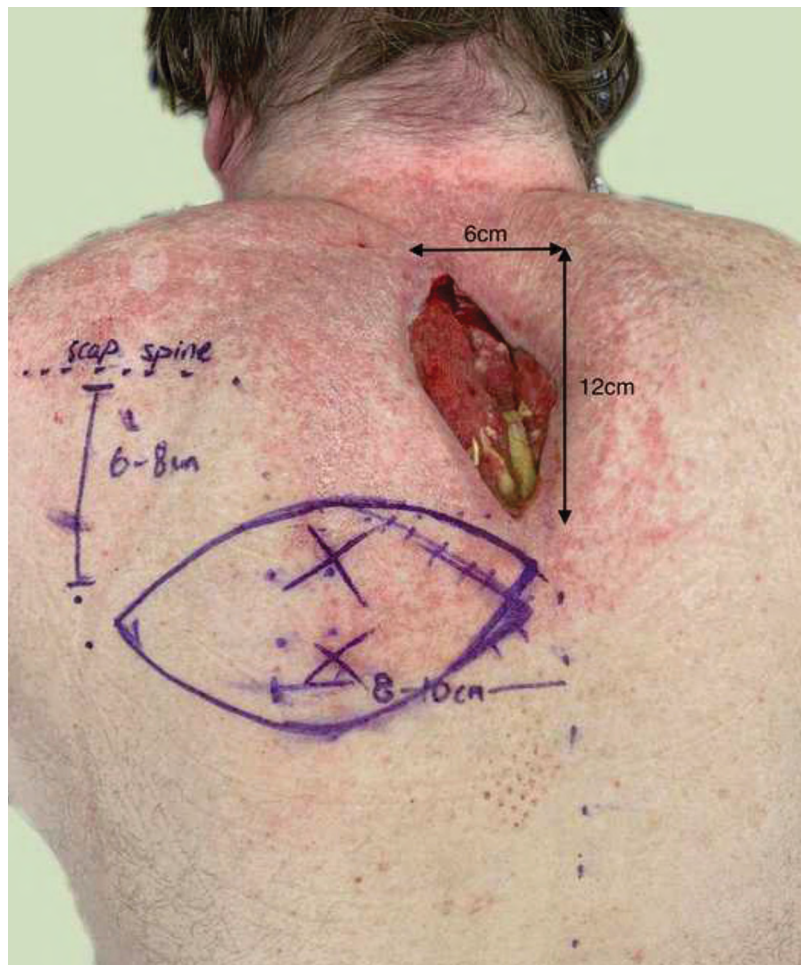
The defect and markings can be seen in the image. The Doppler ultrasound was used to identify the dorsal scapular artery perforators 8–10 cm lateral to the midline and 6–8 cm inferior to the scapular spine. Two perforators were found in this region and marked with an “X.”
